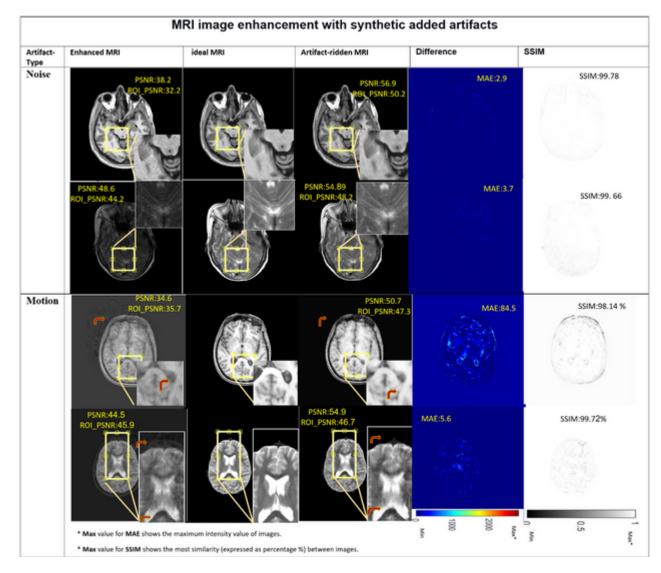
Comparison of "Modified " and "artifact-ridden" images with ideal images from different slices for T1W and T2W MR images by proposed DL mode
